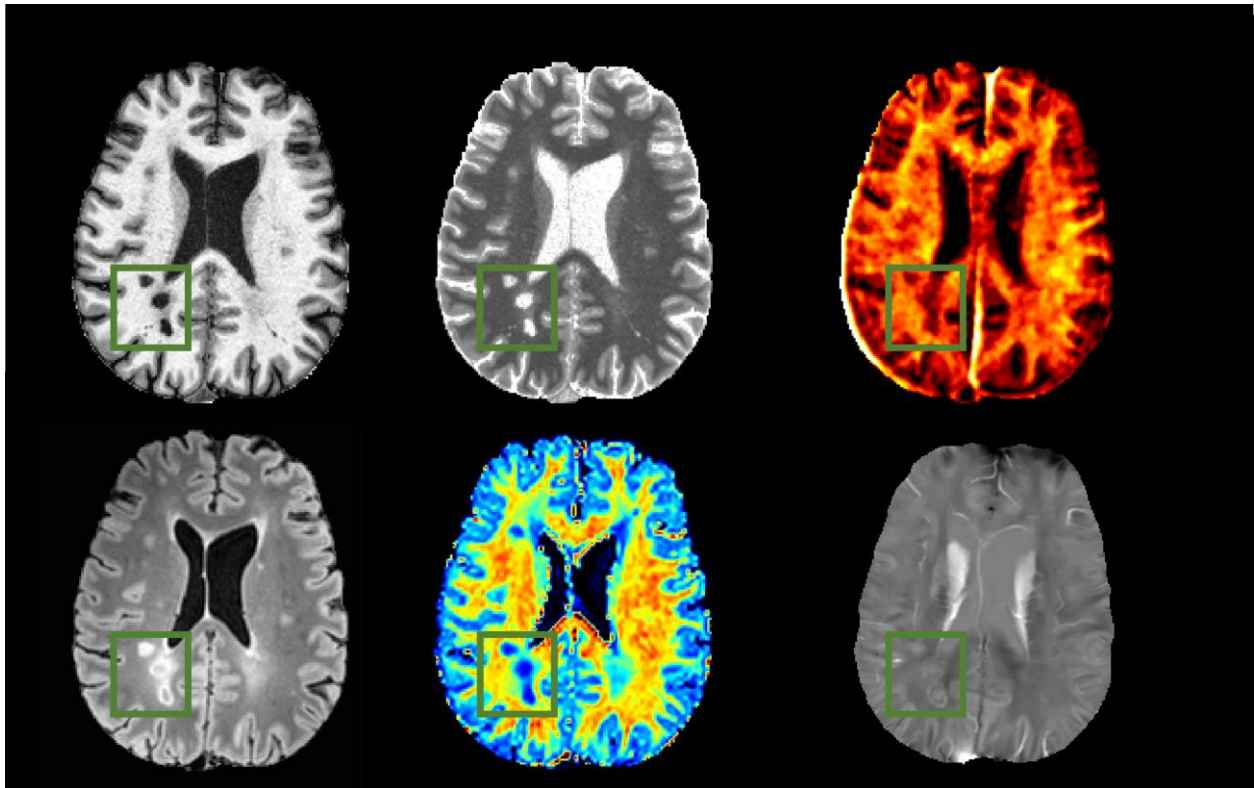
The white matter lesion representations of an exemplar MS patient on qualitative and quantitative MRI. Upper row from left to right: MP2RAGE, quantitative T1 relaxometry, Myelin Water Fraction. Lower row from left to right: FLAIR, NDI from NODDI and QSM. Lesions are indicated by the green squares. On MP2RAGE, lesions are hypointense and their centers can evolve like black holes. On quantitative T1 relaxometry, lesions are hyperintense because the demyelination and axonal damage increase the T1 relaxation time. On MWF, demyelination decreases the water in the myelin sheath, so lesions are hypointense. On FLAIR, the same process increases the T2 relaxation time and leads to hyperintense lesions. On NDI, the axonal damage and loss reduce the neurite density and thus lesions are hypointense. On QSM, lesions have rims formed by the iron-laden macrophages at the lesion boundaries, which are paramagnetic.
